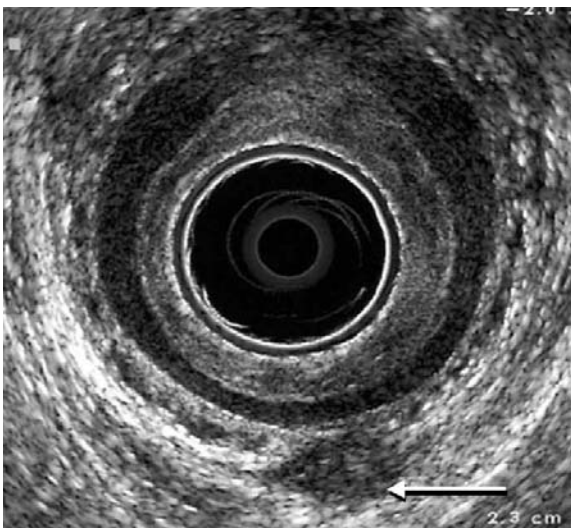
Anal endosonography shows a collection in the right posterior quadrant of the ischioanal fossa (arrows). Loss of peripheral signal makes it difficult to trace this in its entirety (see Fig. V.49)
